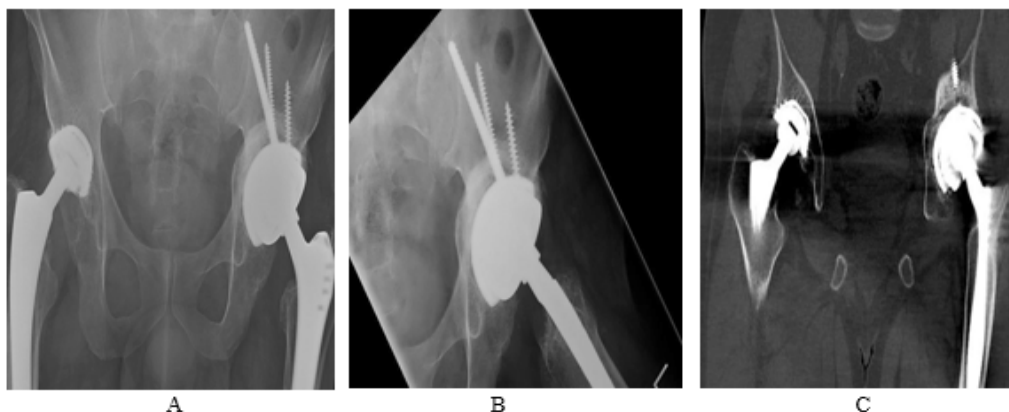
One year after revision of the left hip. pelvic (a), lateral (b) radiographs and coronal (c) computed tomography scan.
